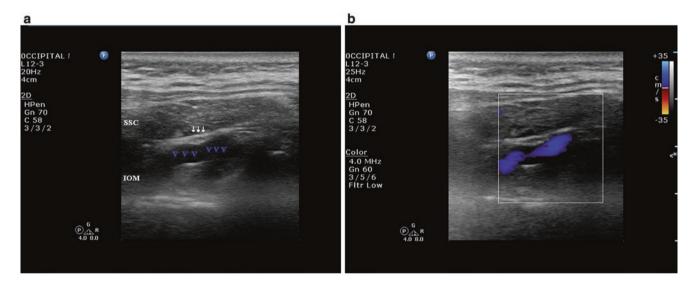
(a, b) Short-axis sonogram at C1–C2 level showing an abnormal vein (VV) impinging the greater occipital nerve (arrows) as it runs between the inferior oblique muscle (IOM) and the semispinalis capitis (SSC). (Figure b with color Doppler)
